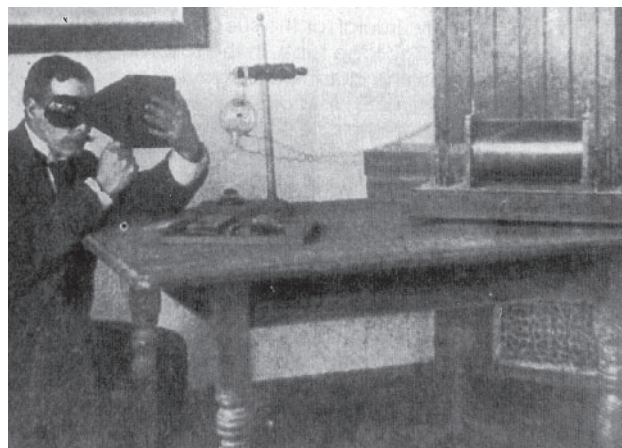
The classical posture of the radiation pioneer, shown in 1896 using his hand to test the hardness of the x-ray beam. The term "hardness" was used to describe the energy of the x-ray beam: the more penetrating the x-ray, the harder the beam. An x-ray beam that was too soft would not pass through the tissue of the hand onto the film; one that was too hard would not be stopped by dense material such as bone, and contrast on the film would be lost. Therefore, operators often used their own hand as the imaging object, adjusting the unit to balance penetrability with contrast. Repeated exposures of this type over several years cost many their fingers and hands.
